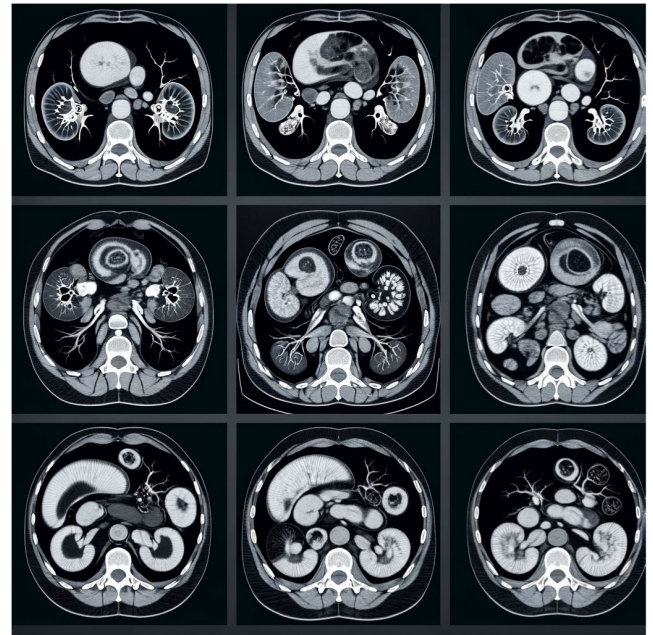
Synthesized the missing slices, enhancing the quality of the CT scan images.
